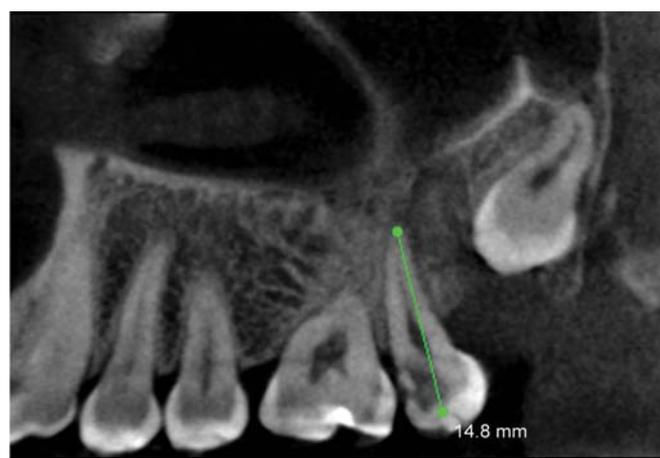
CBCT image (approximate canal length of palatal canal)
